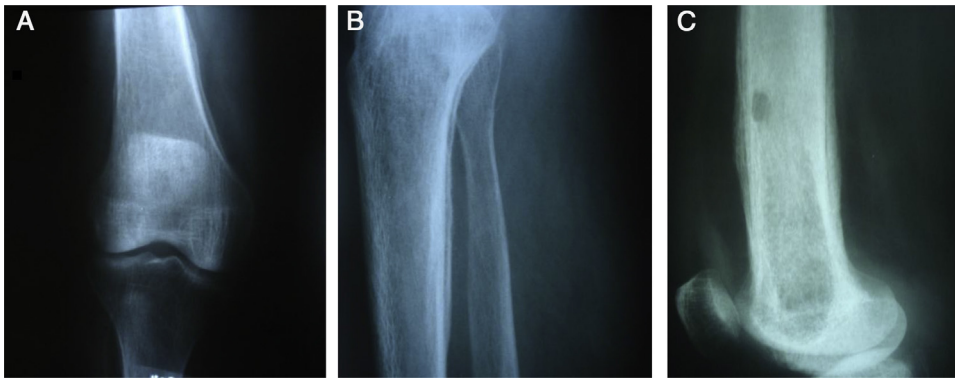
Radiographic appearance of the lesion. (A) Radiograph in anteroposterior view showing periosteal reaction in the femur. (B) Radiograph in lateral view showing periosteal reaction in the tibia. (C) Radiograph in lateral view showing distal femur after the operation, with a bone window for drainage, curettage, culturing and biopsy, and showing the various layers of the periosteal reaction.
